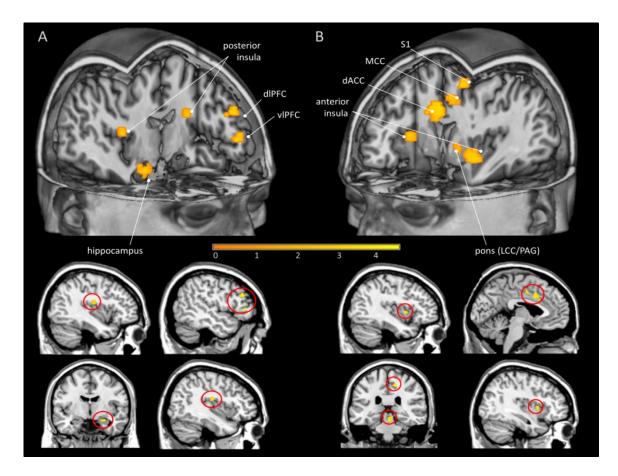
Differential neural responses for visceral compared to somatic pain. Enhanced neural activation was revealed in cingulate, insular, sensory-motor, hippocampal, prefrontal and midbrain regions for (A) somatic pain [PAIN_{VIS} < PAIN_{SOM}] and (B) visceral pain [PAIN_{VIS} > PAIN_{SOM}] combined for the ascending and plateau phase of pain stimulation [in all contrasts: $p_{FWE} < .05$; for details, see Tab.3]. Activations were superimposed on a structural T1-weighted MRI used for spatial normalization and thresholded at p < .001 uncorrected for visualization purposes. Color bars indicate t-scores. For more details on BOLD data analyses, see Tab.2 and result section (4.1.3.2.). Abbreviations: dACC, dorsal anterior cingulate cortex; dlPFC, dorsolateral prefrontal cortex; LCC, locus coeruleus complex; MCC, midcingulate cortex; PAG, periaqueductal gray; S1, primary somatosensory cortex; vlPFC, ventrolateral prefrontal cortex.
